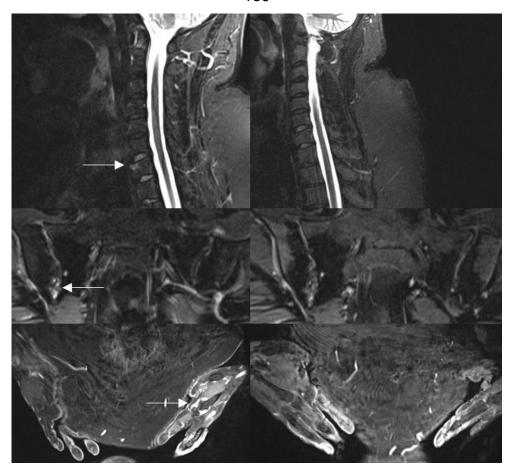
Effects of GOLMePsA Intervention on Magnetic Resonance Imaging Findings
